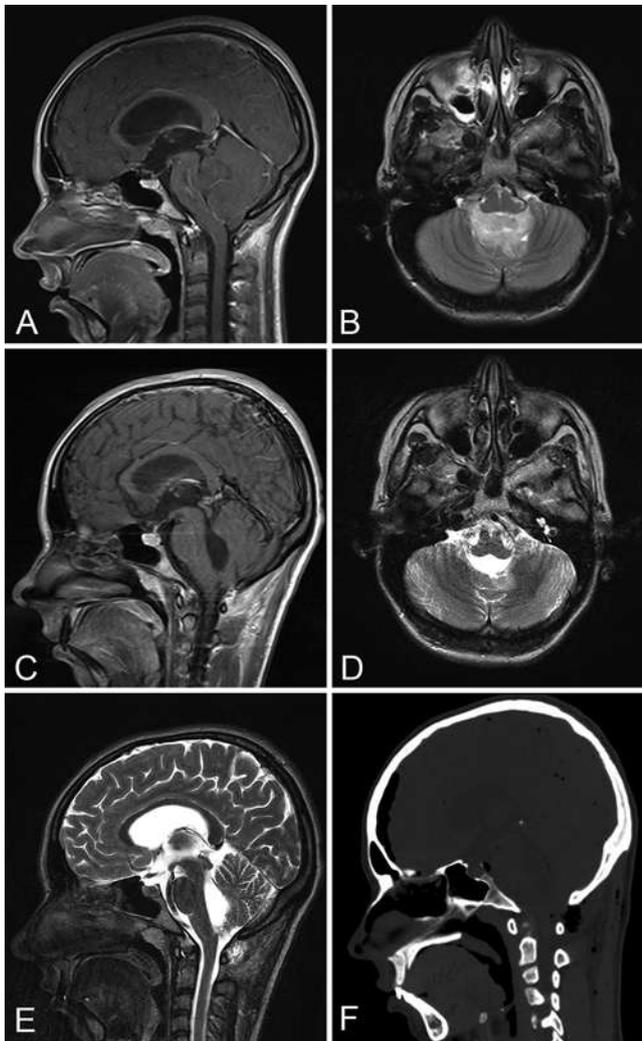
Case 8. Resection of medulloblastoma of the fourth ventricle through the AOM. A and B: Sagittal T1-weighted (A) and axial T2-weighted (B) MR images revealing a large tumor completely obliterating the fourth ventricle and expanding toward the lateral recess, with poor contrast enhancement. C–E: Sagittal contrast-enhanced T1 and T2 MR images at 2 months postoperatively on sagittal (C and E) and axial (D) planes revealing gross-total tumor removal. F: Postoperative CT scan of the midsagittal skull reconstruction demonstrating the absence of craniectomy.
